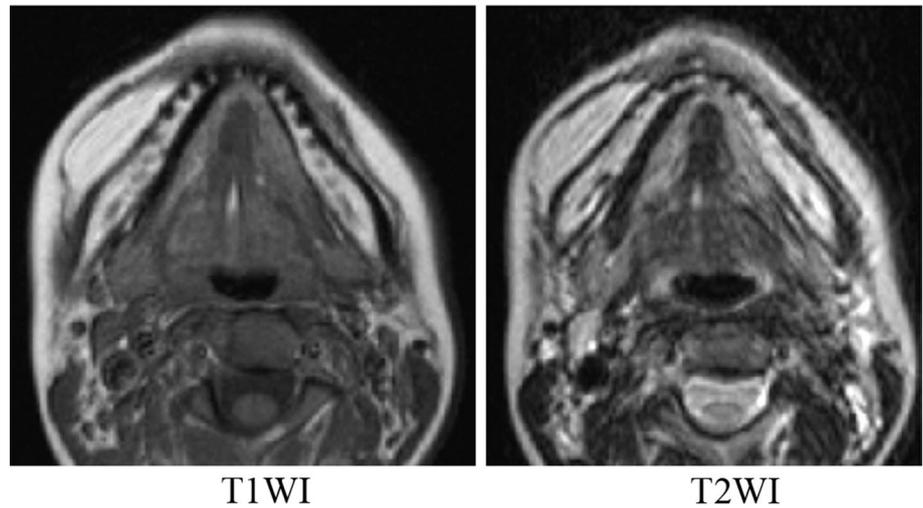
Magnetic resonance imaging of a ranula. The lesion in the left submandibular region is depicted as having a low signal in T1-weighted images and high signal in T2-weighted images. Therefore, the contents can be defined as water
